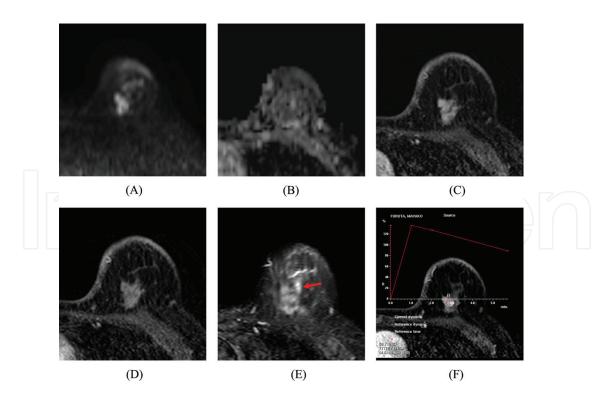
(A) Diffusion-weighted image of b-1000 shows mass like high signal intensity. (B) Apparent diffusion coefficient (ADC)-map reveals diffusion limitation of the water molecule. (C) Contrast-enhanced T1 weighted images demonstrate early enhancement and (D) delayed washout pattern. (E) The mass included a small high-signal intensity on fat-saturated T2 weighted image, which is confirmed pathologically as extracellular mucin (arrow). (F) Dynamic-curve of the MRI shows rapid washout pattern.
